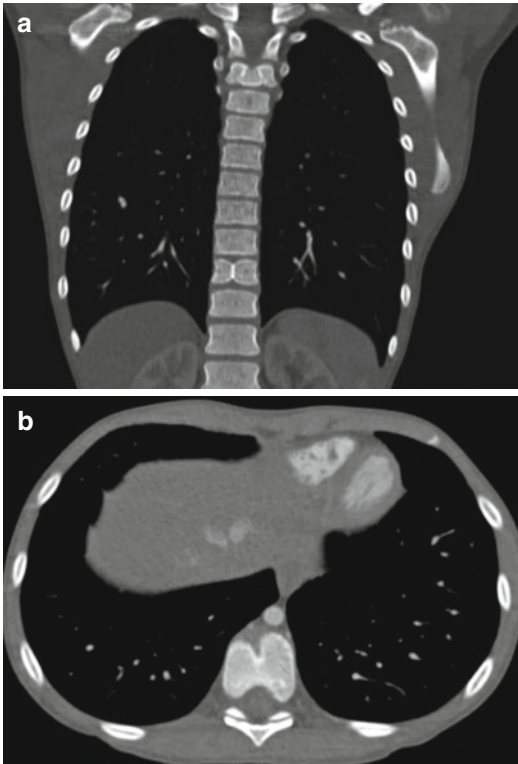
CT scan with vertical reconstruction (a) and cross section (b) demonstrating butterfly vertebra at T10 (Courtesy of Dr. Sabah Servaes, CHOP)
